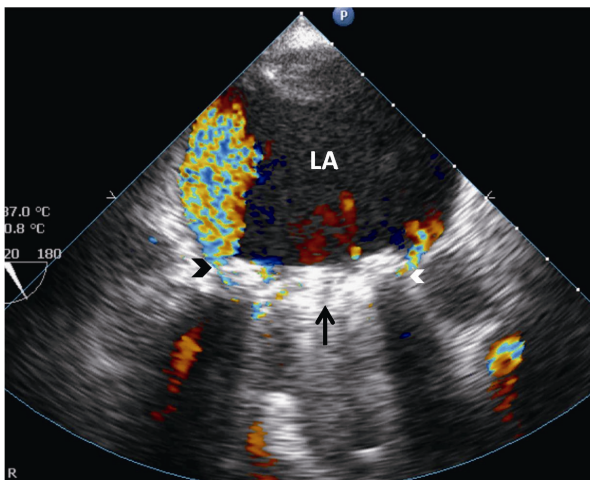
Transesophageal echocardiography demonstrating a bileaflet mechanical prosthesis in mitral position (black arrow), large paravalvular leak (black arrowhead), and trivial leak (white arrowhead). LA: left atrium.
